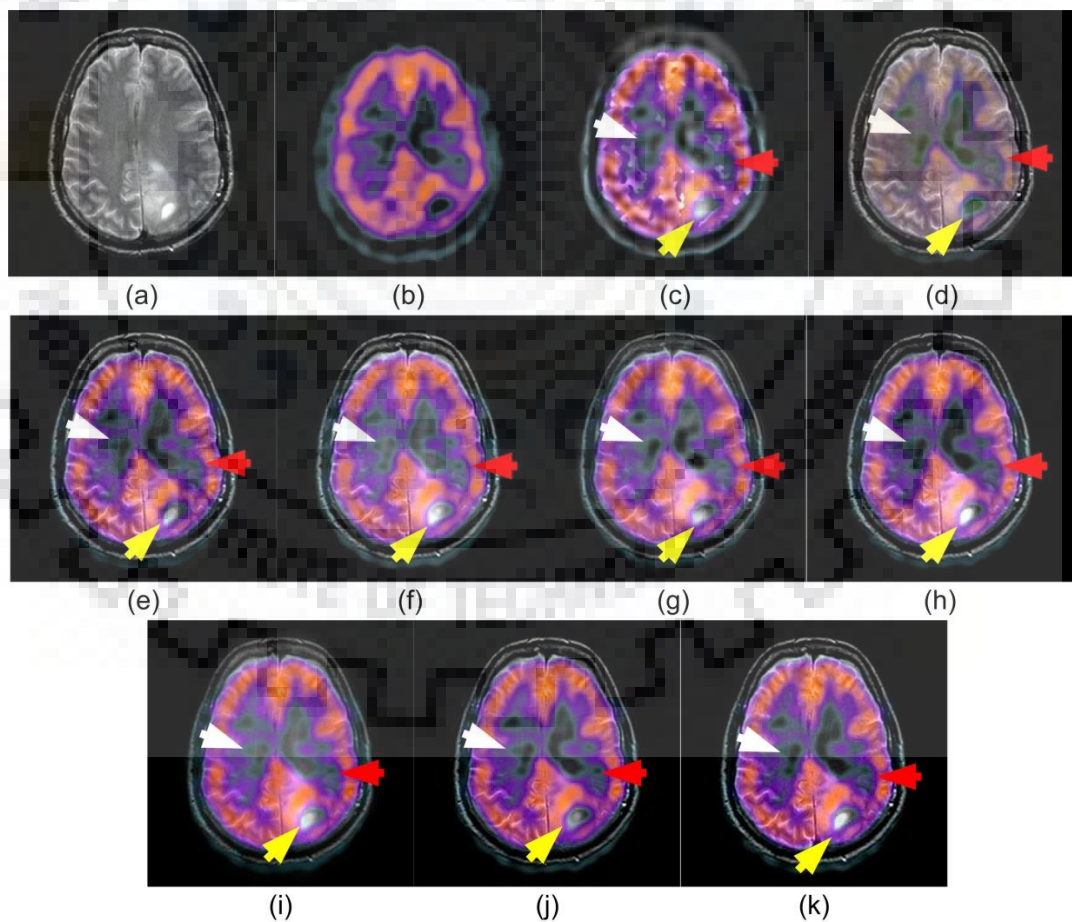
Input image pair-1 (a) MR image (b) SPECT image, qualitative comparisons of fused images obtained by (c) Bhatnagar et al., 2013 [18] (d) Li et al. 2013 [94] (e) Yang et al., 2015 [200] (f) Yang et al. 2016 [201] (g) Yang et al., 2017 [203] (h) Liu et al., 2017 [111] (i) Hermessi et al., 2018 [57] (j) Hou et al., 2019 [59] (k) Proposed CNN-MIF
